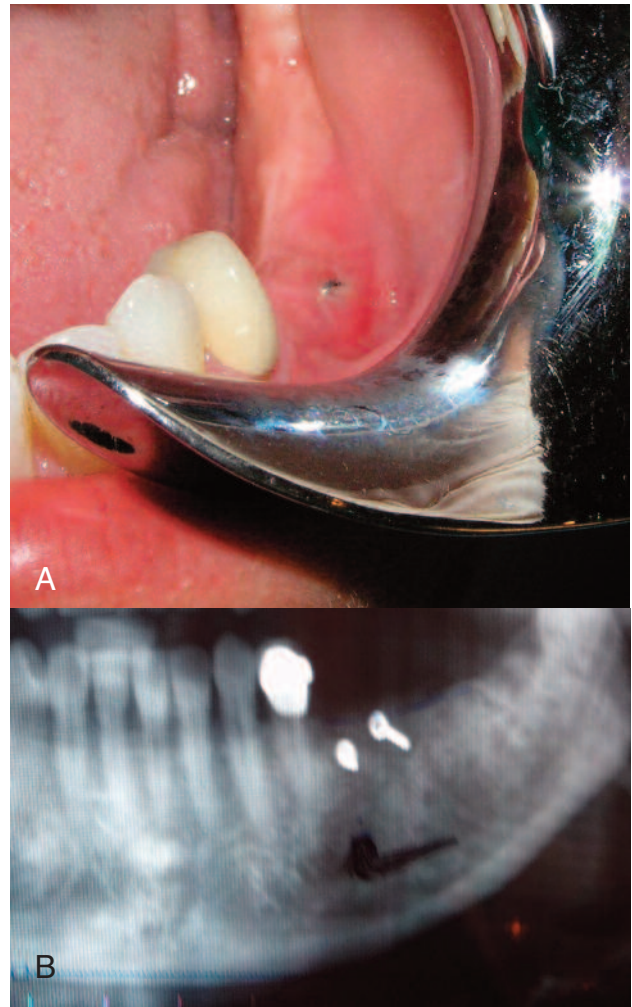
Clinical case 7. A, image in which minimal exposure of the head of the fixation screw is seen at the fourth postoperative month. B, radiographic follow-up image at the fourth postoperative month.
